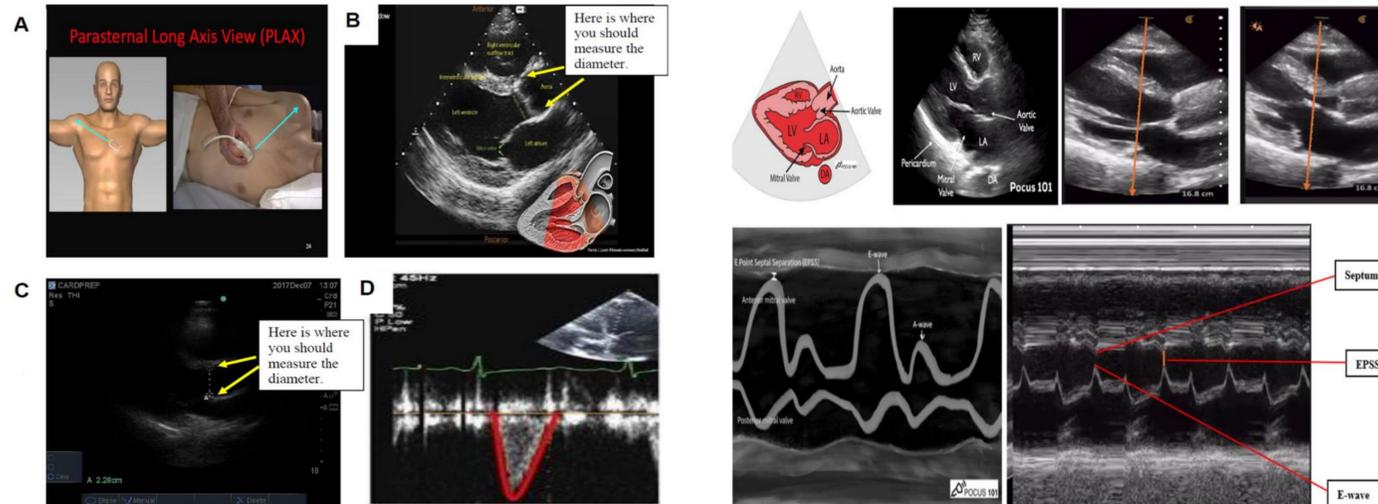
Use of POCUS PLAX view to measure aortic/LVOT diameter and LVOT VTI. A. PLAX view POCUS probe placement. B. PLAX view. C. PLAX view. D. Doppler and PLAX view to calculate LVOT VTI.
